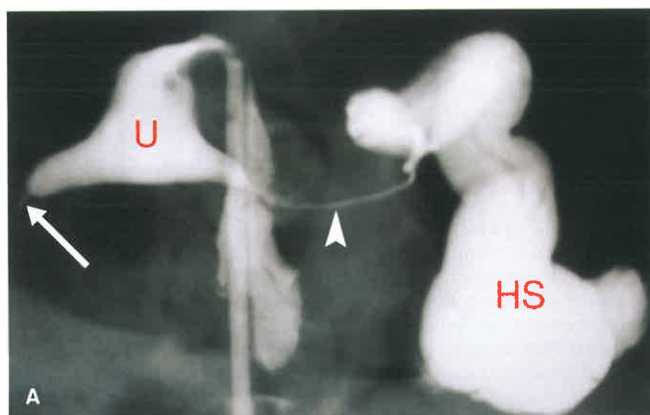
Hydrosalpinx. A: HSG demonstrates a retroflexed uterus (U) with the fundus directed posteriorly and inferiorly. The right fallopian tube is occluded at the isthmus (arrow). The left fallopian tube is massively dilated at its distal end, forming a hydrosalpinx (HS). The proximal portion (arrowhead) of the left fallopian tube is normal. No peritoneal spill of the injected contrast agent is present indicating bilateral total tubal occlusion. B: Axial T2-weighted MR in a different patient demonstrates a similar appearance of hydrosalpinx (arrows) as a dilated twisted convoluted tube on the right.
